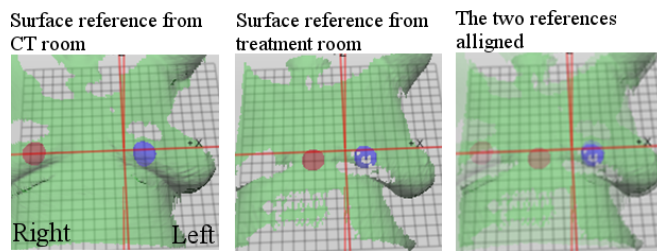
Example of spatial movement of the gating area (red circle) from the original placement at the right breast (set in CT room) to the area above the xiphoid process in the treatment room. The inadequate signal reception at the right breast can be verified as holes in the captured surface. In the clinical setting at HGH, the gating area is primarily set at the xiphoid process in the CT room, and if inadequate signal reception occurs it should initially be set at an area that is still near to the xiphoid process; but it can be necessary to set it at the target (if no bolus is present) or contralateral breast.
